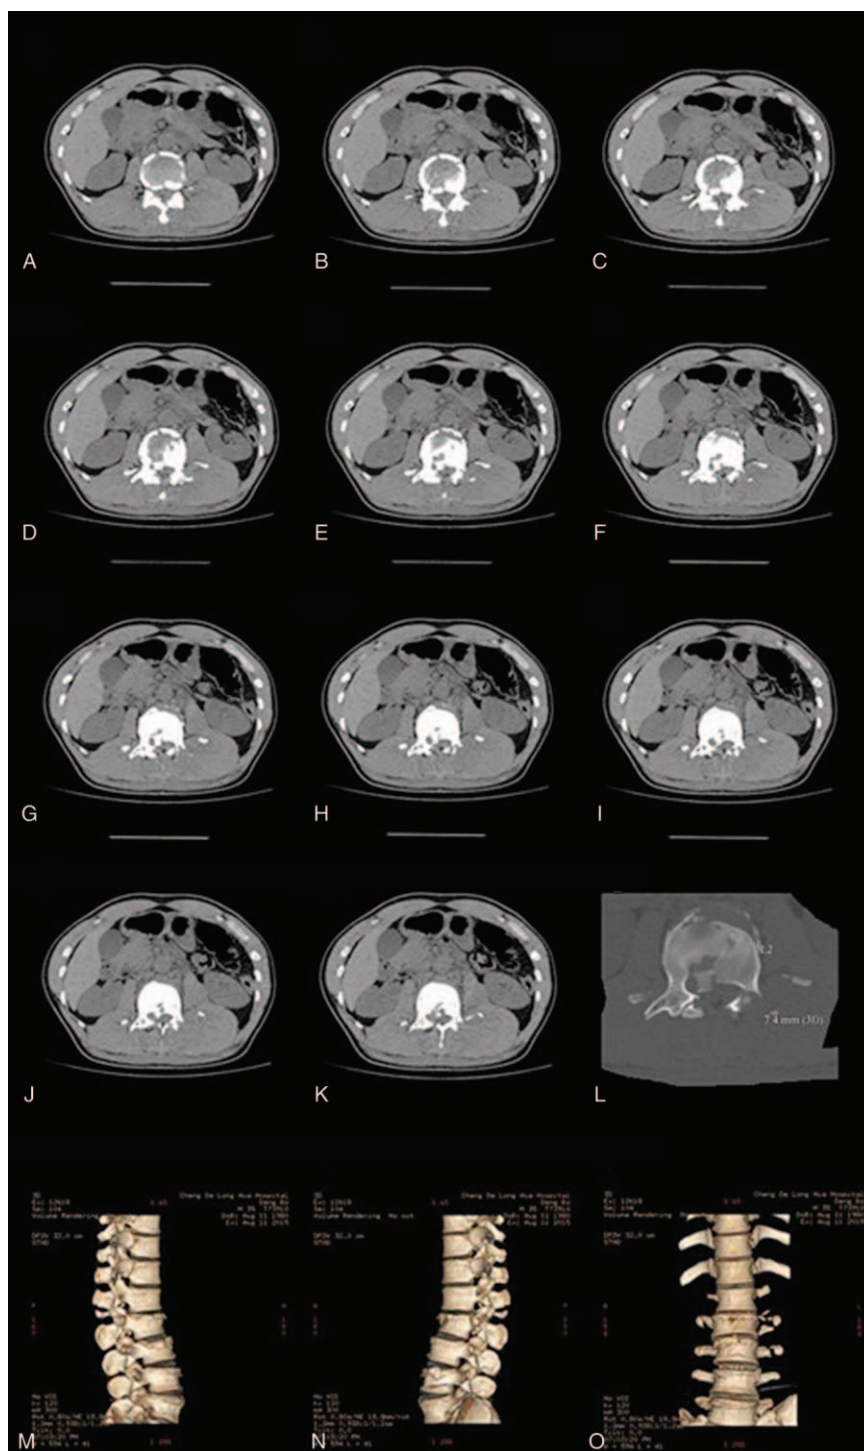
Computed tomography showing: Magerl type A3.1 burst fracture and facet disorder (A–K). A bone fragment 7.4 mm in diameter that had breached the spinal canal on the posterior edge of the vertebral body at L2. (L) Damage to the cortices of the left transverse processes of the vertebrae at L1 and L3, and left and right transverse processes of the vertebra at L2 (O). 3D computed tomography showing damage to the right interior facet and spinous process of the vertebra at L1 and the ipsilateral superior facet of the vertebra at L2 (M–O).
